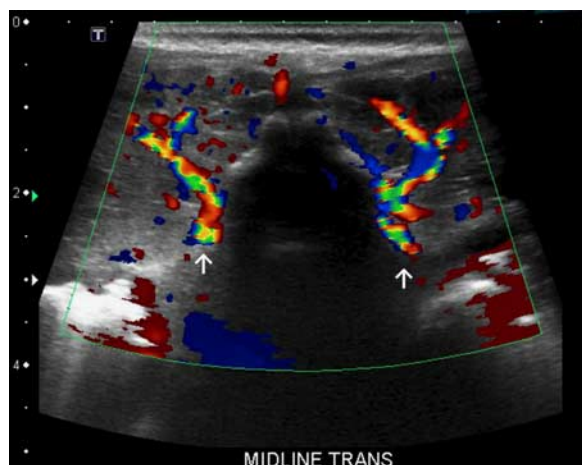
Curvilinear transducer with color Doppler image from a posterior approach shows increased vascularity (arrows) to the paraspinal dorsal muscle groups.
